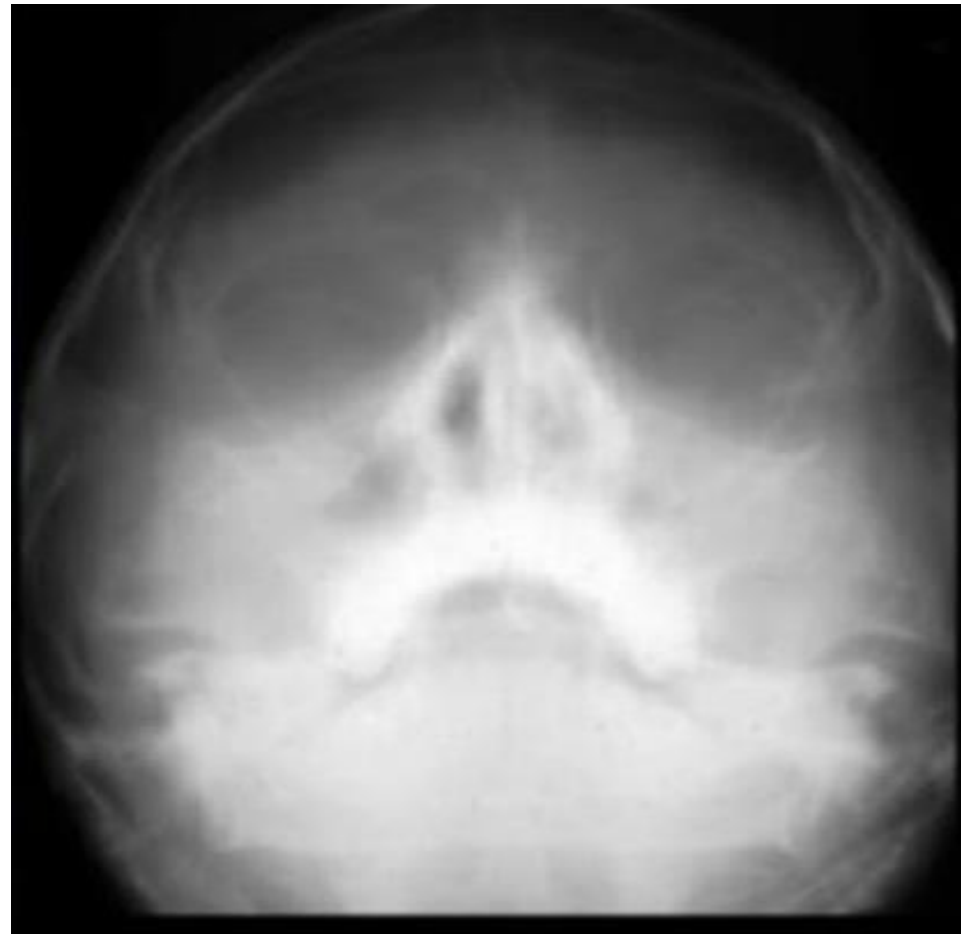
X-ray of Paranasal sinus viewing mucosal thickening and haziness of maxillary sinus
